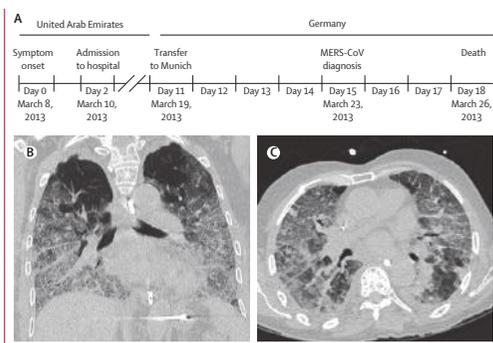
Disease and treatment. (A) Chronology. Frontal (B) and horizontal (C) CT scans done on day 12 of disease, showing intense basally-pronounced congestions indicative of atypical pneumonia and acute respiratory distress syndrome. MERS-CoV=Middle East respiratory syndrome coronavirus.
